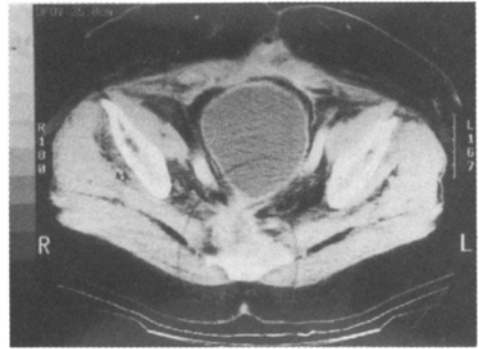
6 mon. later, the RII finding was proved by CT scan during the course of follow – up.
